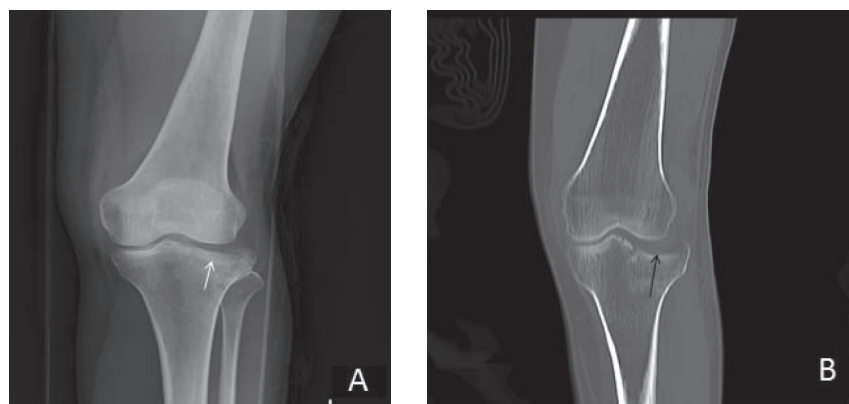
The left knee images of a 55-year-old female patient. (A) Antero-posterior XR image shows pure compression fracture of the lateral tibial plateau (white arrow), Schatzker III. (B) Coronal CT scan shows pure compression fracture of the lateral tibial plateau (black arrow), Schatzker III representing good concordance.
